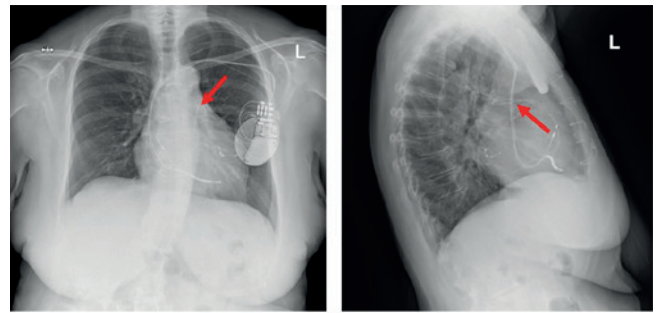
Chest X-ray taken 6 years post implant following suspicion of pacing lead displacement or migration (left = posteroanterior, right = lateral projection). The red arrows on the images identify the slack of the left ventricular pacing lead in the MPA. All three lead tips appear to remain in the same position as at implant, including the left ventricle lead which remains in a posterolateral branch of the coronary sinus. The generator does not appear to have rotated or shifted.
